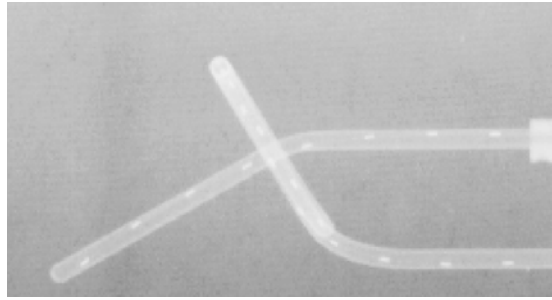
Perpendicular "lateral" X-ray exposure for ring 60° and 40 mm probe with marker wire.
